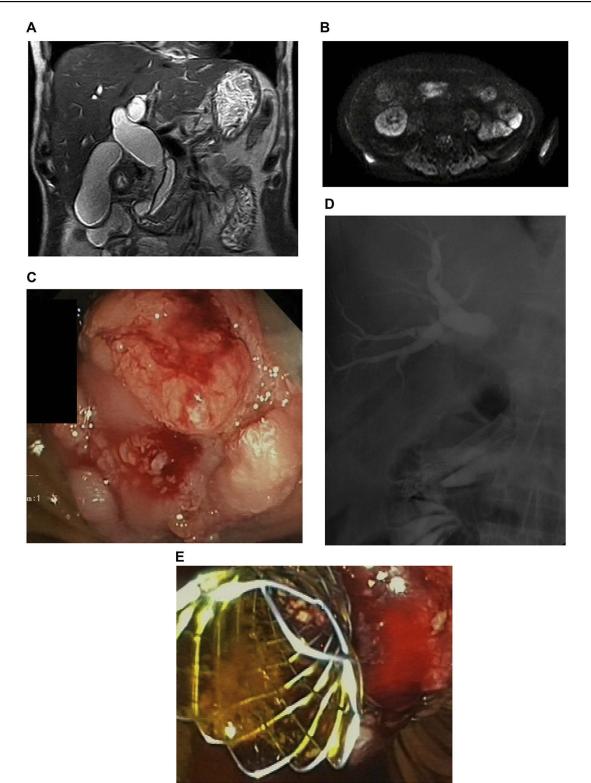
Figure I A 69-year-old presented with abdominal pain and cholestasis. MRI showed a double duct sign and a suspected lesion at the papillary area (A), presenting an abnormal diffusion-weighted signal and suggestive of an ampulloma (B). ERCP revealed an ampullary mass (C) and standard biopsies were performed confirming the diagnosis of ampullary carcinoma. A 10mm USEMS of 6 cm of length is placed to relieve the obstruction (D, E).
